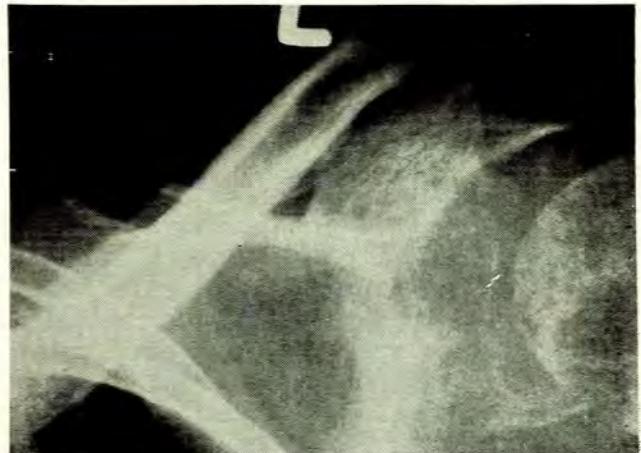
X-ray of the left shoulder showing destruction of bone in glenoid and in the head of the humerus.
